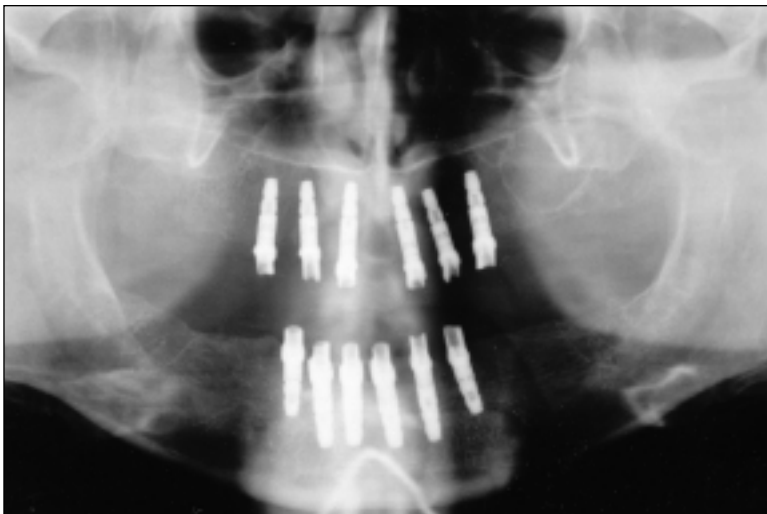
Orthopantomogram. The patient received 6 Frialit-2 screw implants (Friatec) placed in prosthetically favorable positions in the maxilla and the original irradiated (70 Gy) mandible.
